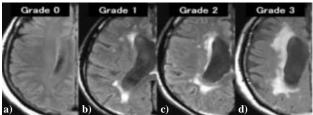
Periventricular hyperintensity (PVH) grading of magnetic resonance images (11), a) grade 0, no lesion, b) grade 1, in the form of a line or a cap, c) grade 2, irregular hyperintensity and/or smooth halo, d) grade 3, lesion spreading to the periventricular region and deep white matter
